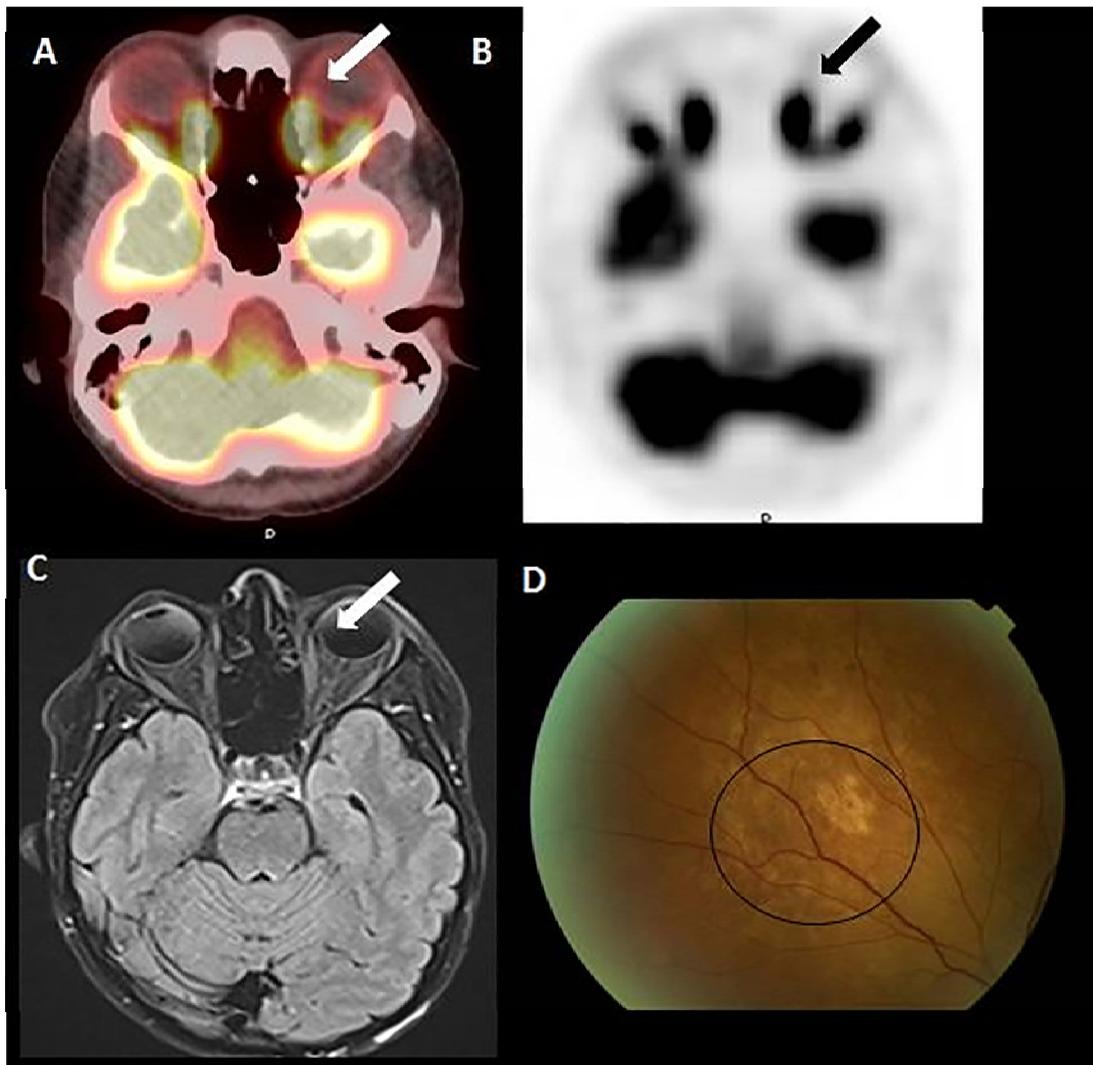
Axial ^{18}F -FDG PET (A), fused PET/CT (B) and MRI axial FLAIR (C) showed resolution of focus of FDG-uptake and choroidal thickening in the left nasal choroid (arrows). Photograph of the fundus (D) revealed regression of the choroidal mass (circle).
